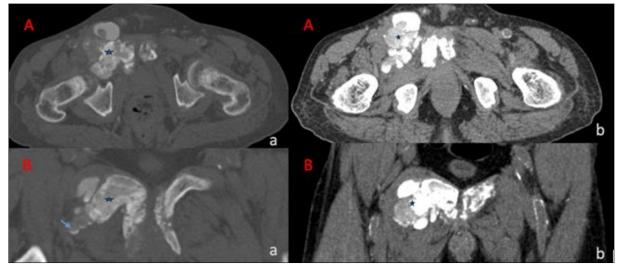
Pelvic CT scans in axial (A) and coronal (B) views, using bone window (a) and soft tissue window (b), showing a lobulated mass (*) centered on the right side of the pubic symphysis and extending to the right iliopubic and ilio-sacral branches. The lesion contains multiple heterogeneous, dense, and cystic calcifications, some of which demonstrate fluid-fluid levels (blue arrow)
